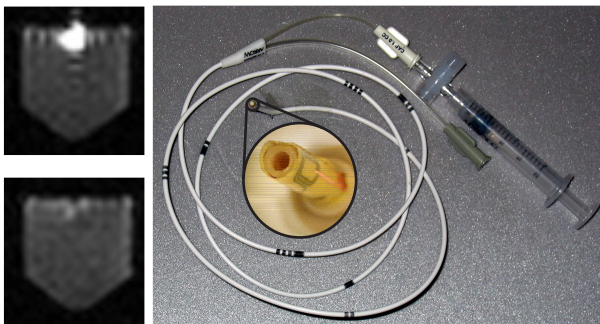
MR images of the optical detuned and tuned state of the resonance circuit and image of a prototype of the MR catheter with special catheter-tip.
